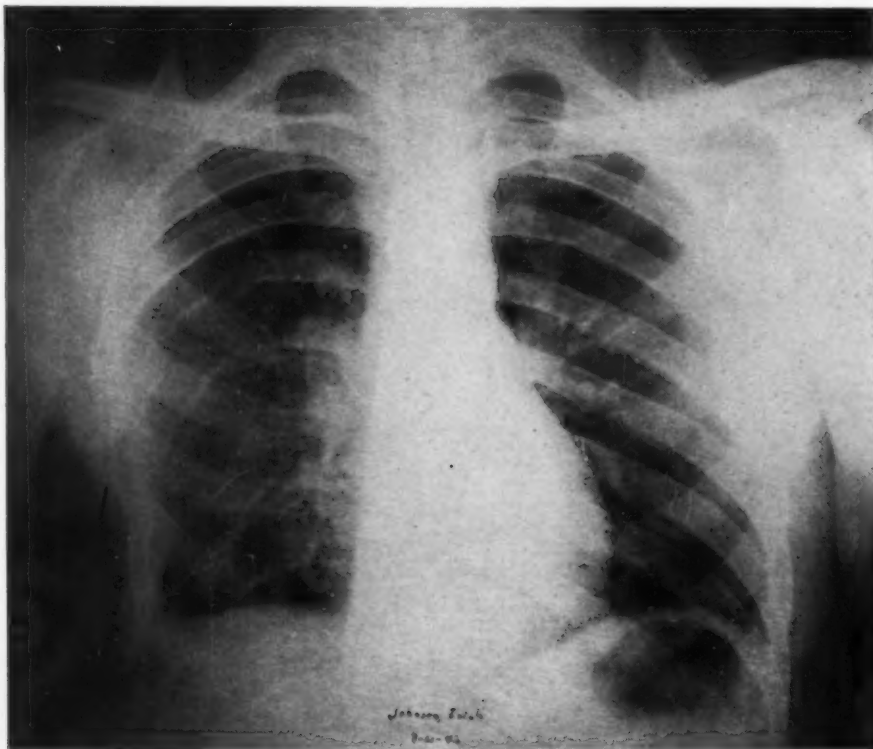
Post-operative x-ray of the chest showing appearance following resection of portions of the 5th to 10th ribs inclusive on the left for chronic empyema with multiple bronchopleural fistulae. In this case, it was not necessary to remove the posterior ends of the ribs. There is a coincident situs inversus in this patient which was apparently not significant.
